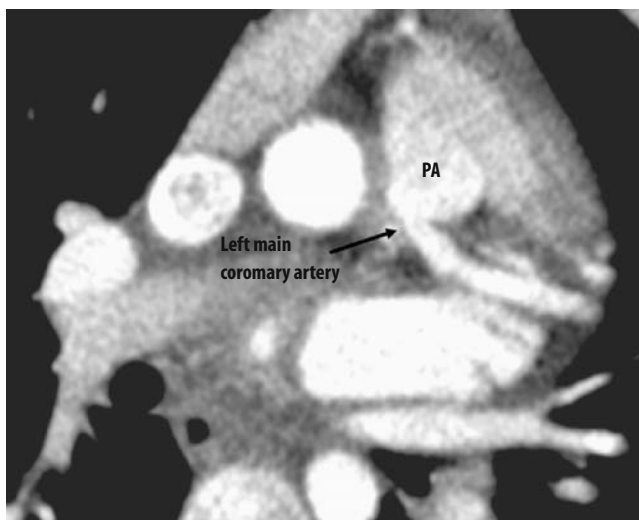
CT angiography image demonstrating anomalous origin of the left coronary artery off of the pulmonary artery (arrow), which is a substrate associated with sudden cardiac death. PA = pulmonary artery.
